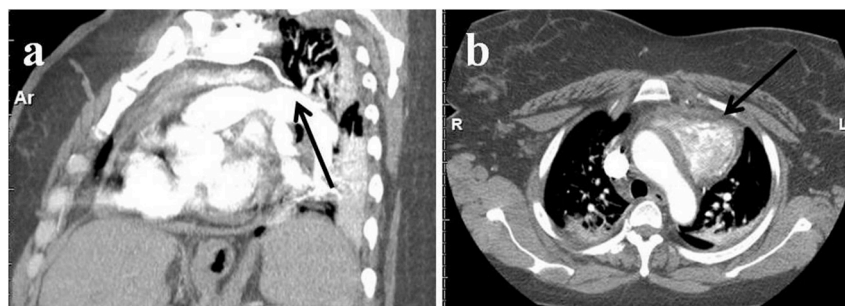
CT Angiography: 3a: sagittal view: The tip of the catheter is outside of the PA, no active extravasation of contrast is seen (arrow), 3b: transverse view: 3cm mediastinal hematoma (arrow).
